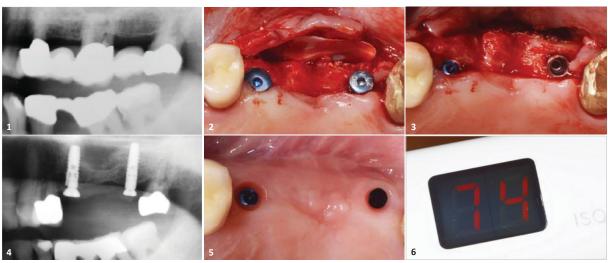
Tooth 26 has been severely damaged below the crown. - Fig. 2: Autologous bone, PORESORB-TCP (LASAK), and a collagen membrane... - Fig. 3: ... prior to suturing - Fig. 4: Postoperative radiograph. The gingiva former on tooth 25 must be retightened. - Fig. 5: The situation after open healing. - Fig. 6: The ISQ value recorded after exposure.
